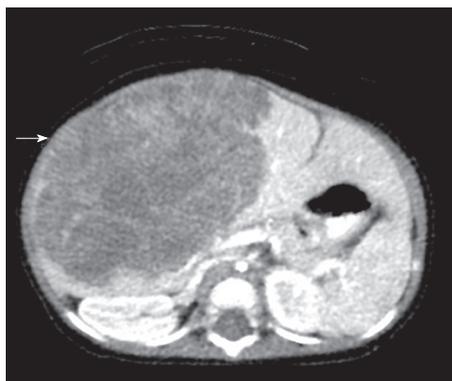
Hepatoblastoma. Axial computed tomography scan after the injection of IV contrast material in a 7-mo-old girl demonstrates a poorly enhancing large mass within the liver (arrow).
